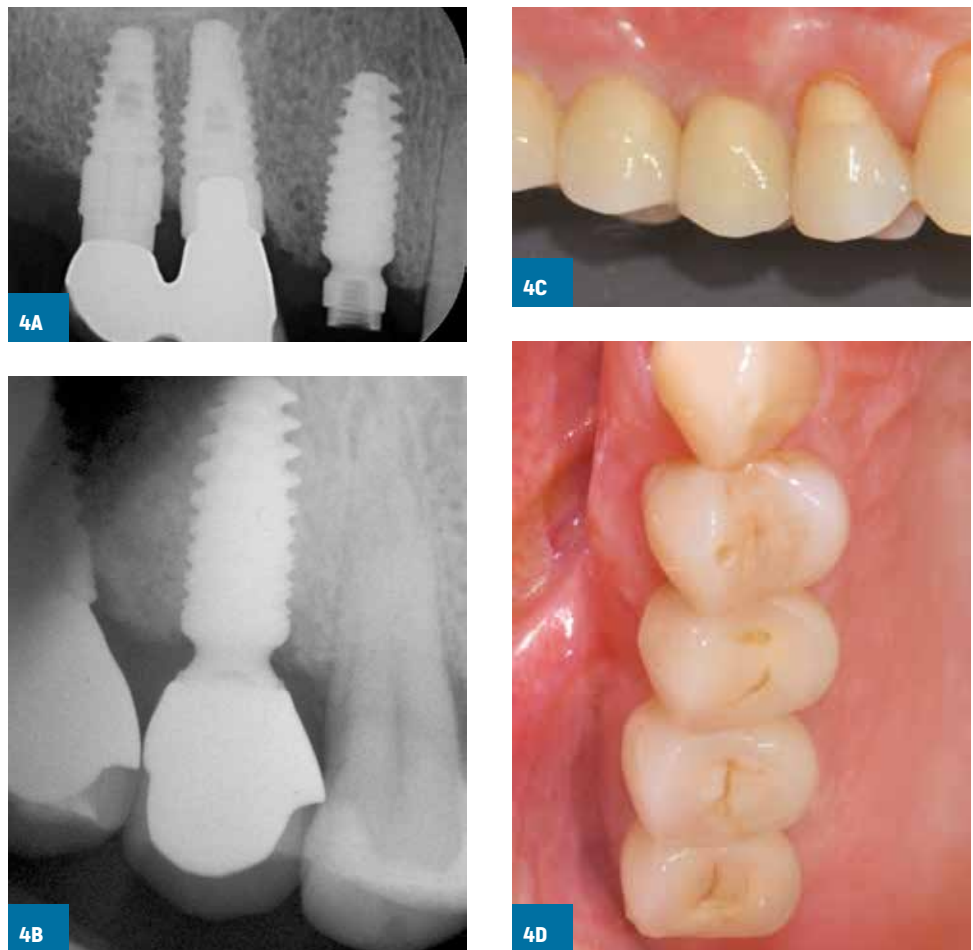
Treatment sequence of a patient randomly allocated to a subcrestally positioned implant rehabilitated with a screw-retained crown: immediate postoperative baseline periapical radiograph [A], and periapical radiograph [B], vestibular [C] and occlusal [D] view at 4 months after loading.
